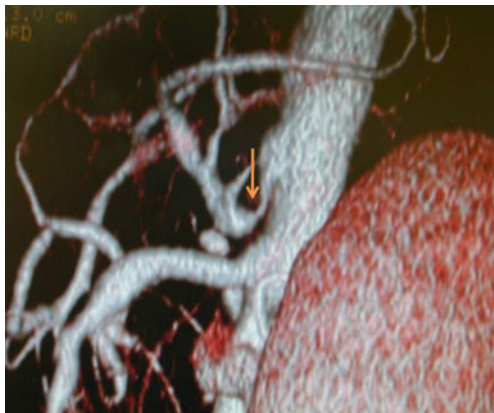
3D CT reconstruction, showing the stenosis of celiac artery seemed to be extrinsic compression.
